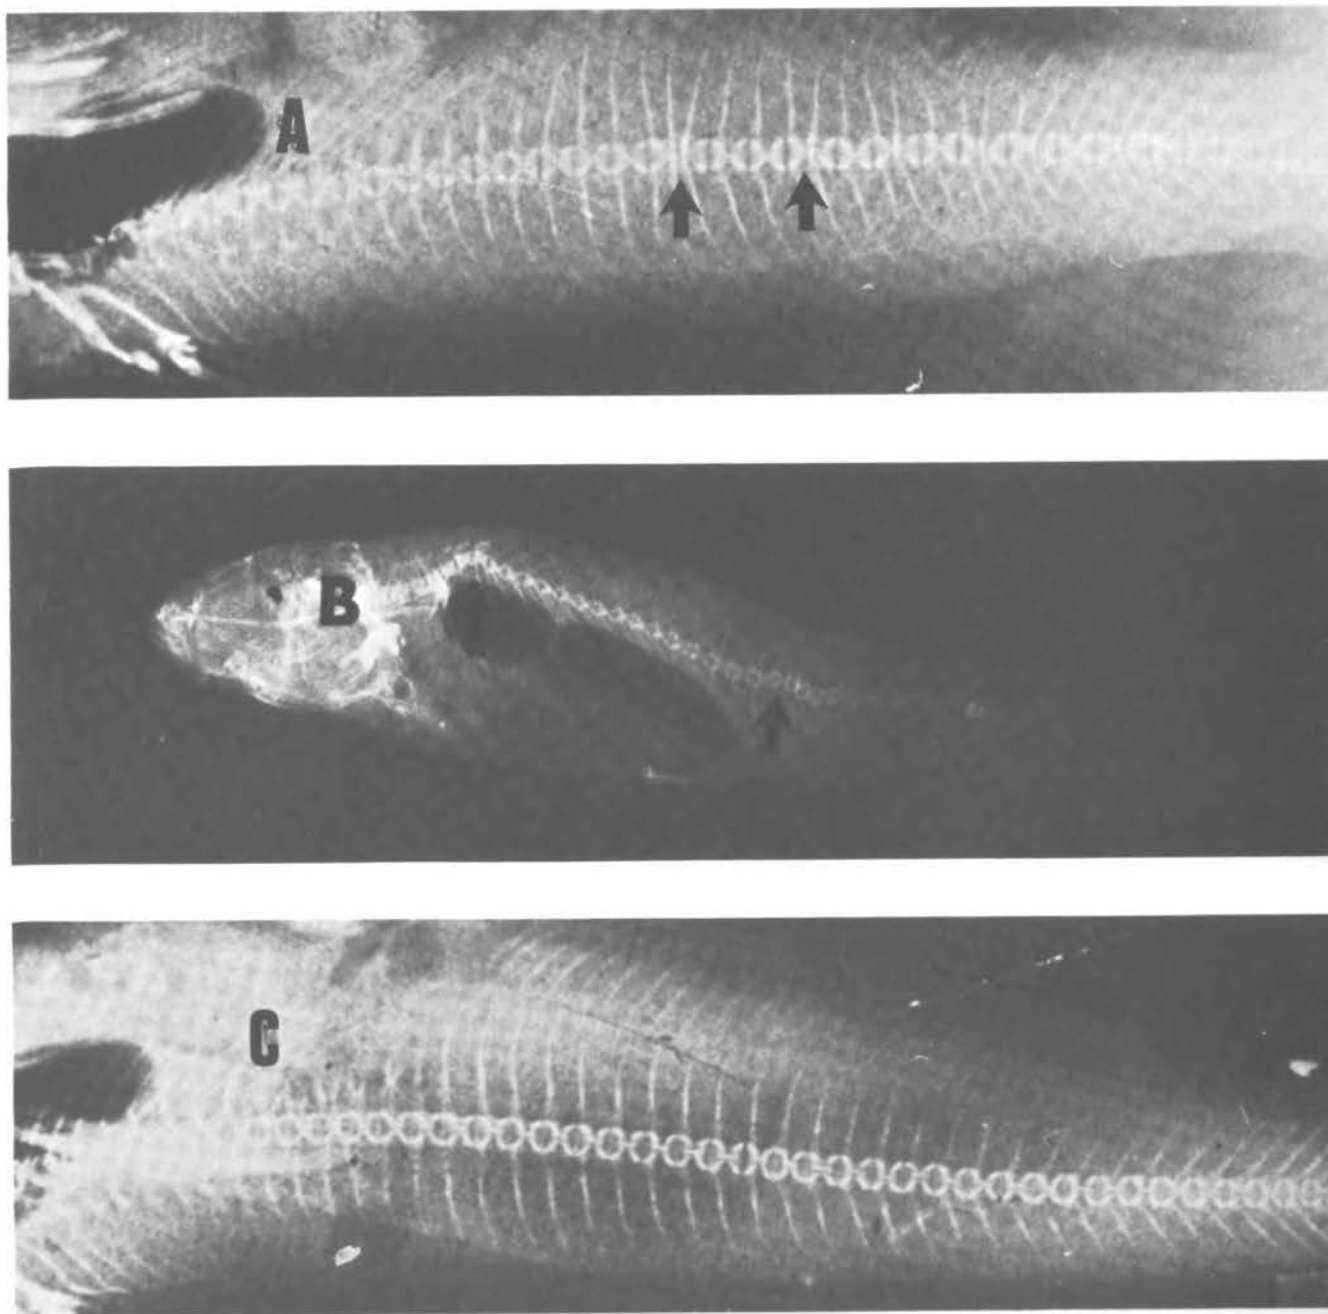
Radiographs showing the effects of toxaphene on the backbone structure of channel catfish (A) and fathead minnow (B). Backbone of a normal catfish (C) does not show deformity. Channel catfish (A) was exposed to 44 ng of toxaphene per liter of water and fathead minnow (B) was exposed to 55 ng of toxaphene per liter of water. Arrows indicate areas of affected backbone. (Photographs by Mehrle and Mayer, 1975.)
